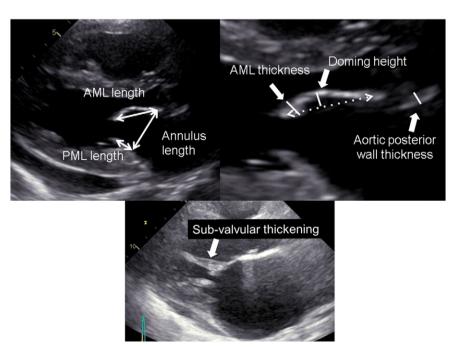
Actual transthoracic echocardiogram measurement of the mitral valve (MV) leaflet at end-diastole in the parasternal long axis view. Upper Left Figure: Anterior (AML) and posterior mitral leaflet (PML) and annuls length of MV were measured. Upper Right Figure: AML thickness, AML doming height, and aortic posterior wall thickness were measured. AML thickness index was calculated as the ratio of AML thickness to that of the aortic posterior wall thickness. Lower Figure: Typical image of MV sub-valvular thickneing.
